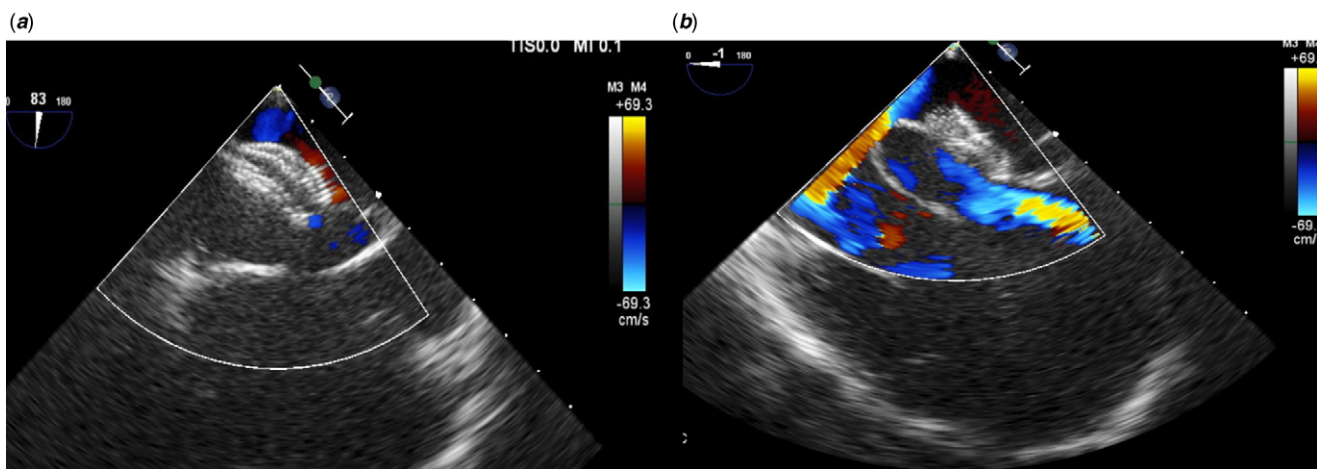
(a and b) Control transoesophageal echocardiography showed no residual shunt on the amplatzer septal occluder.
